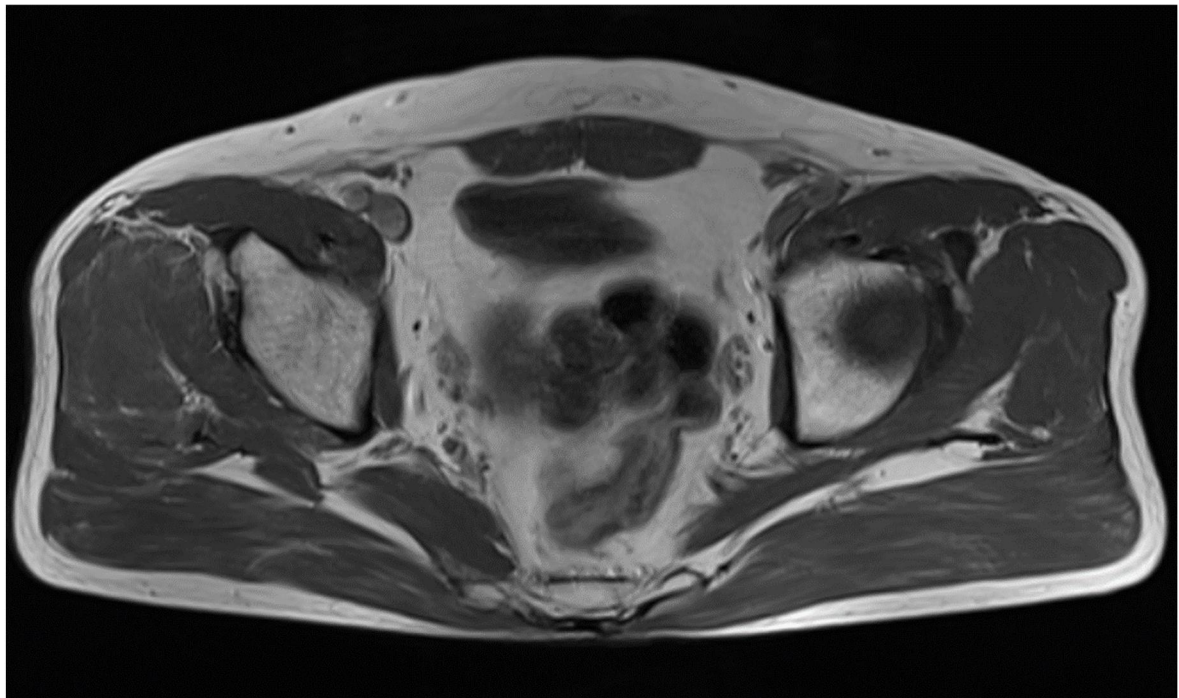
Axial T2-weight magnetic resonance imaging showed the asymmetry of piriformis muscle volume (larger on the right).
